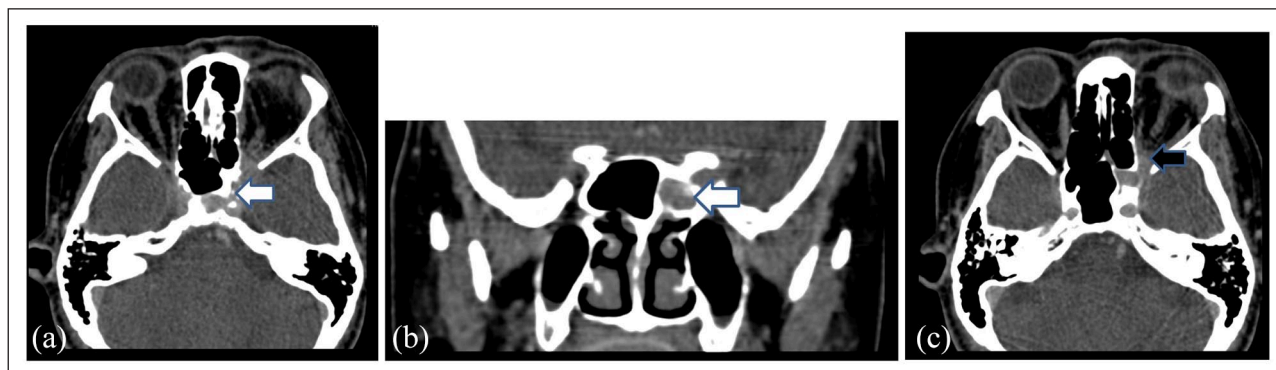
(a, b) Axial and coronal slice CT paranasal sinus at the level of sphenoid sinus with white arrow showing hyperdensities within the mucosal thickening in the left sphenoid sinus. (c) The axial slice clearly demonstrated the pathological involvement of left orbital apex (obliterated fat, black arrow) as compared to the normal right side.
